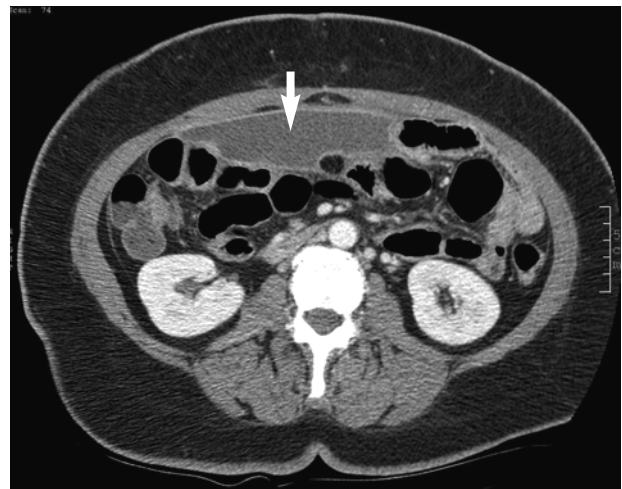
Axial CT-image (5 mm slice thickness): intra-abdominal abscess localized ventral to the small bowel (arrow).
